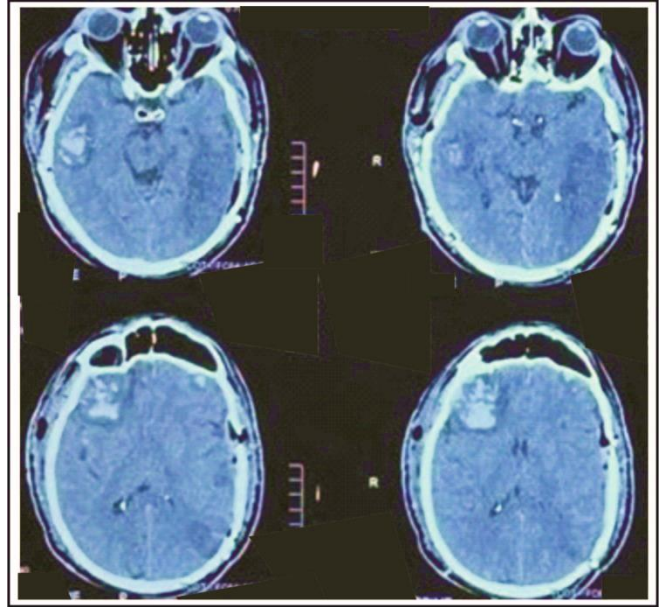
CT scan after the first surgery (Presented with patient's consent).
